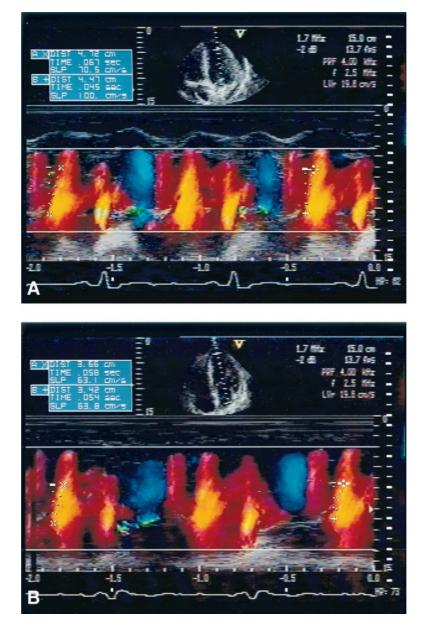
Color M-mode Doppler flow propagation into the LV before (A) and immediately after (B) pericardiocentesis in a patient with cardiac tamponade.
